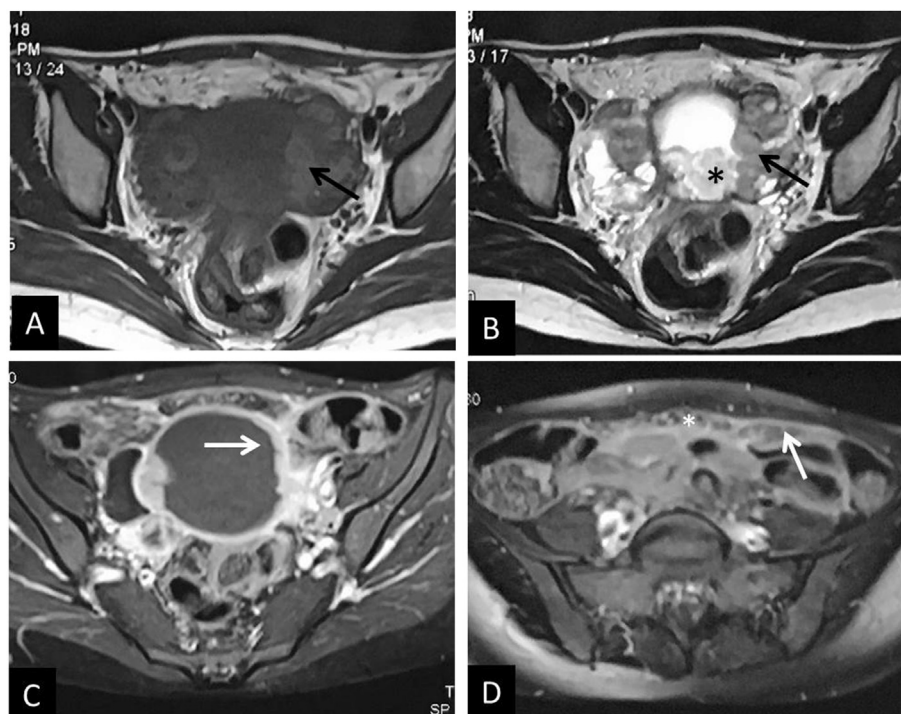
MRI Tuberculosis. A. Axial T1WI (A), T2WI (B) and post contrast axial T1WI (C) reveals bilateral adnexal tubo-ovarian lesions. The tubal component shows T1 hyperintense and T2 Intermediate signal intensity contents (black arrow in A and B). The lesions are cystic with internal debris (* in B) and thick enhancing walls (arrow in C). D. Axial post contrast MRI at a more cranial level reveals peritoneal enhancement (arrow in D) and omental nodularity (* in D).
